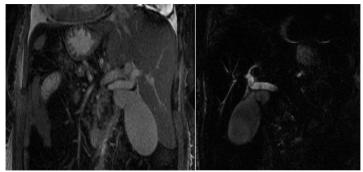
Multisequence MRI Evaluation of the Biliary Tree: Coronal FIESTA and T2
